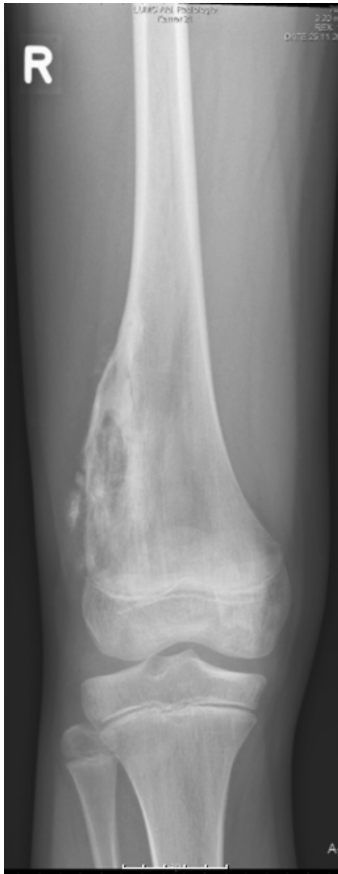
Conventional radiograph demonstrating an osteosarcoma of the right femur in a 13 year old boy. Note the irregular structure of the bony matrix in metaphysis and diaphysis, the periosteal reaction and the extension of the lesion into the soft tissue.
